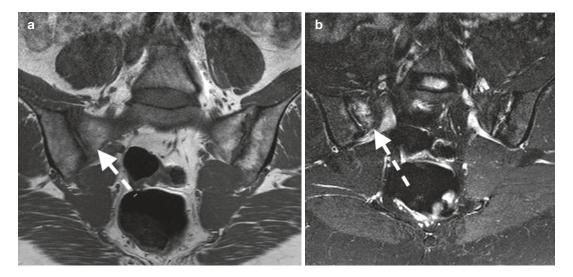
MRI of a marrow edema: (a) Cor T1 and (b) T2FS sacroiliac joint in a patient with acute or chronic sacroilitis with subchondral bone marrow edema (*dashed arrow*)
